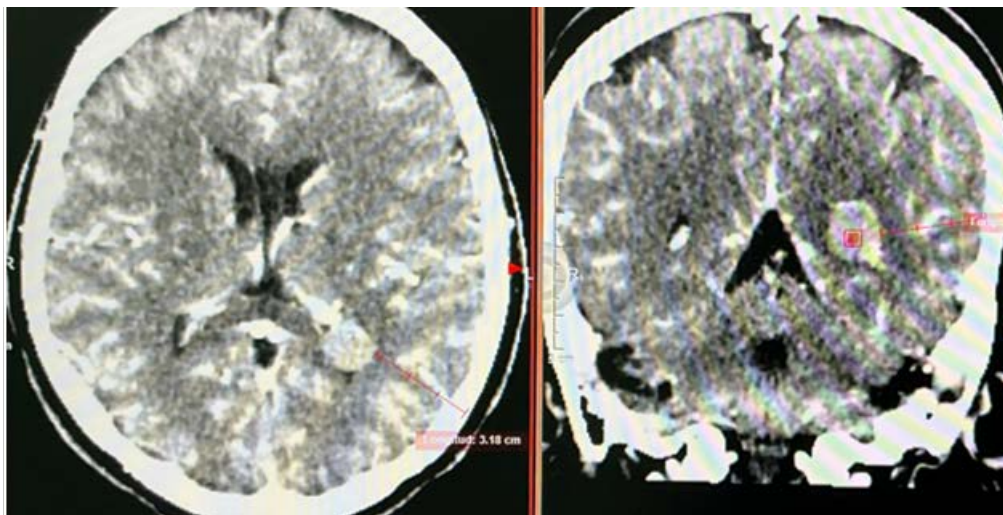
Visualization of a lesion in the left ventricular atrium on CT angiography, demonstrating minimal contrast enhancement and low vascularity.
